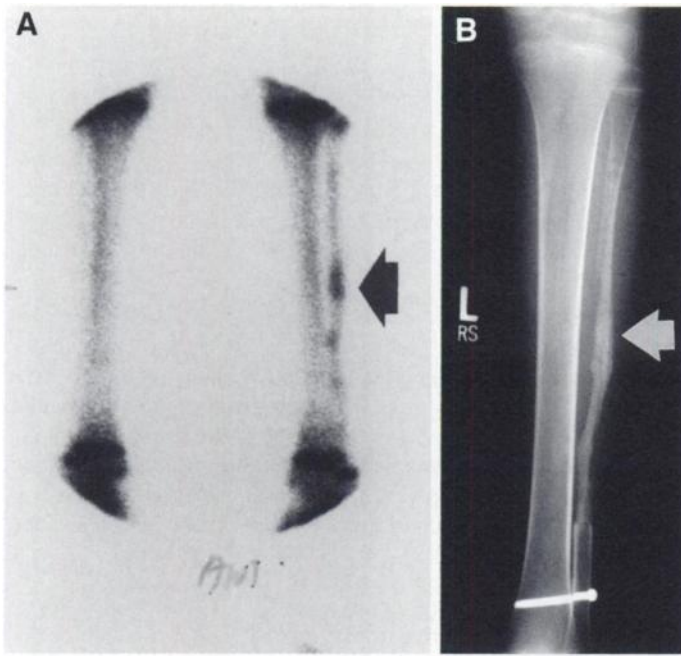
Technetium-99m skeletal scintigraphy in an 11-yr-old boy after resection of Ewing's sarcoma of the third lumbar vertebra and anterior strut fibular grafting. An anterior scintigram of the lower legs (A) obtained after the surgery shows increased radiotracer activity (arrow) along the left fibular donor site, with some focal increased uptake corresponding to the regenerated left neofibula (white arrow) on the frontal radiograph (B).
